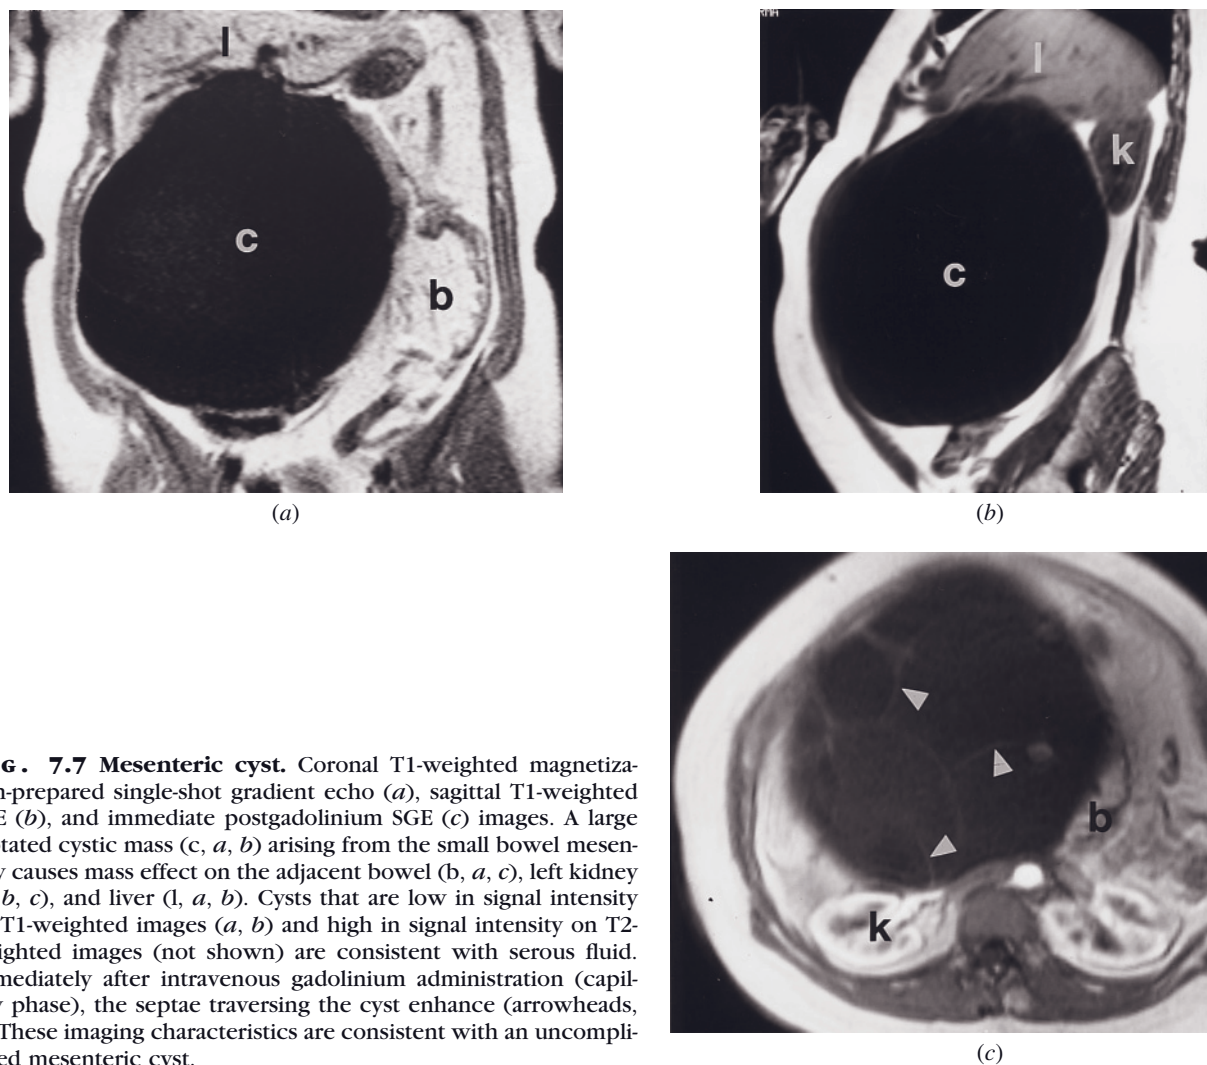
Mesenteric cyst. Coronal T1-weighted magnetization-prepared single-shot gradient echo (*a*), sagittal T1-weighted SGE (*b*), and immediate postgadolinium SGE (*c*) images. A large septated cystic mass (*c*, *a*, *b*) arising from the small bowel mesentery causes mass effect on the adjacent bowel (*b*, *a*, *c*), left kidney (*k*, *b*, *c*), and liver (*l*, *a*, *b*). Cysts that are low in signal intensity on T1-weighted images (*a*, *b*) and high in signal intensity on T2-weighted images (not shown) are consistent with serous fluid. Immediately after intravenous gadolinium administration (capillary phase), the septae traversing the cyst enhance (arrowheads, *c*). These imaging characteristics are consistent with an uncomplicated mesenteric cyst.
